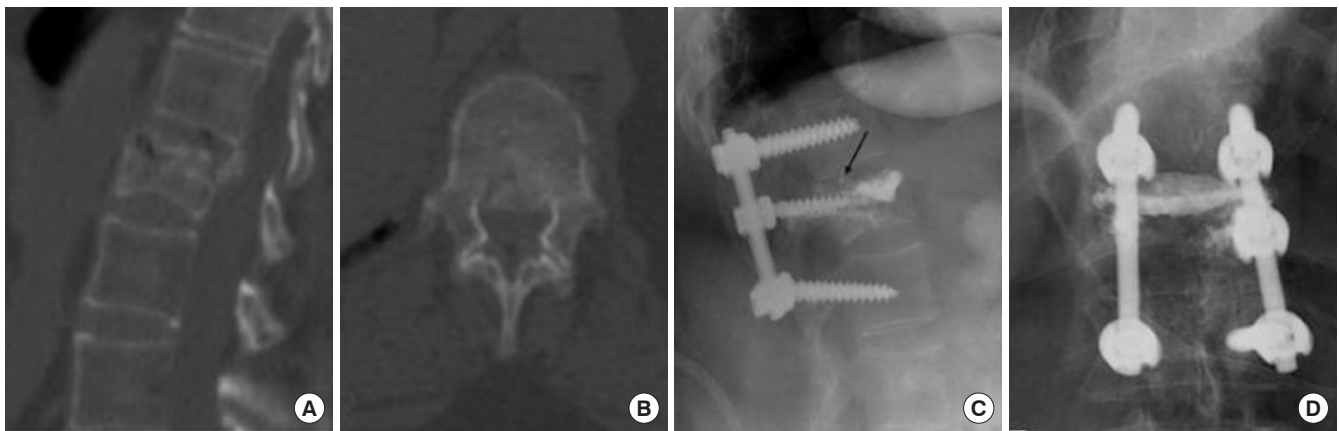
Cement augmentation and screw placement of the fractured level. (A) D12 burst fracture computed tomography (CT) sagittal film. (B) D12 burst fracture axial CT scan. (C) Screw placement with incorporation of fracture segment and cement augmentation lateral view. (D) Screw placement and cement augmentation anteroposterior view.
